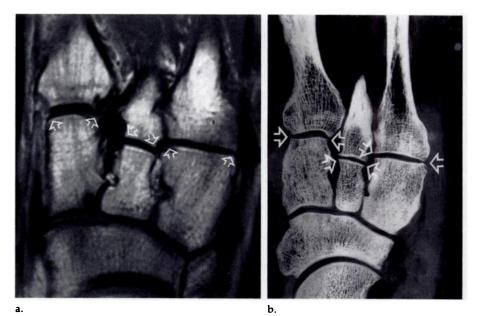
Normal bone alignment (arrows in a and b) between the first metatarsal base and the medial cuneiform bone, the second metatarsal base and the intermediate cuneiform bone, and the third metatarsal base and the lateral cuneiform bone. (a) Oblique axial T1-weighted MR image (400/20, matrix 256 × 256). (b) Radiograph of a section (oblique axial section).
